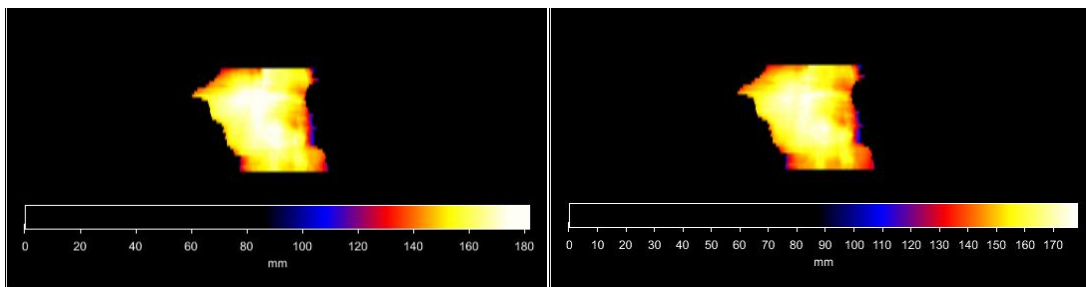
Individual BEV showing accWEPL for planning-CT (left) and weekly-CT (right); example of patient E for weekly-CT 1
